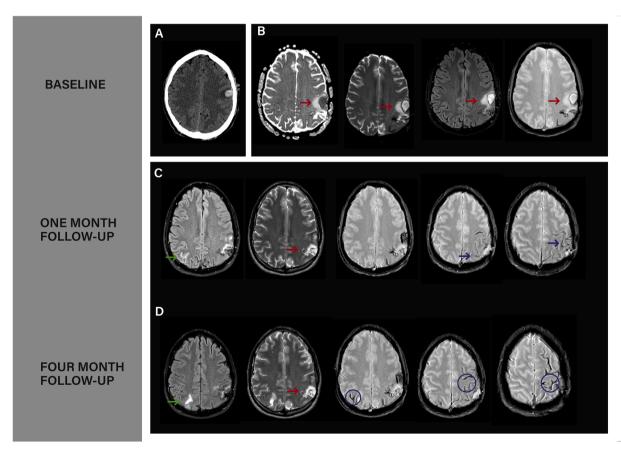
Neuroimaging tests in case 1. A: Baseline brain CT: B. Baseline MRI. C: One month follow-up MRI. D: Four-month follow-up MRI. Arrows in red show the intracerebral hemorrhage. Arrows in blue show cortical superficial siderosis. Arrows in green shows new subarachnoid hemorrhage. Circles in blue show new cortical superficial siderosis.
